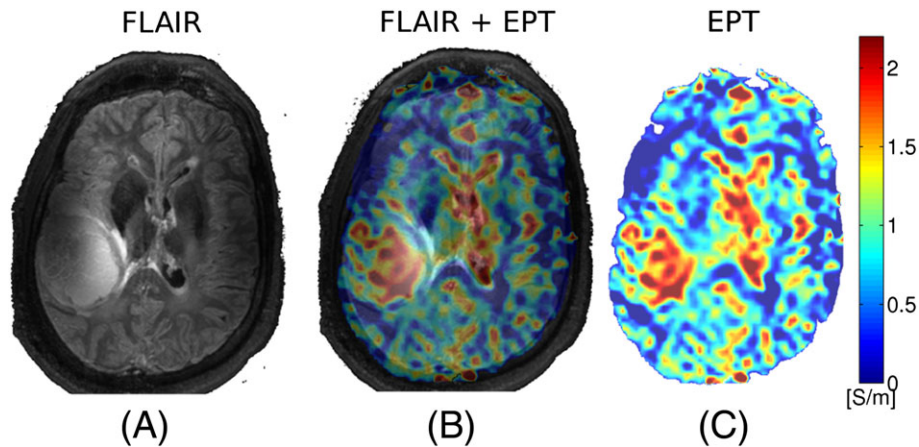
Example of grade IV astrocytoma measured at 7 T: A, fluid-attenuated inversion recovery (FLAIR) image; B, FLAIR image overlaid with reconstructed conductivity; C, reconstructed conductivity. Figure taken from van Lier et al¹⁰⁹
